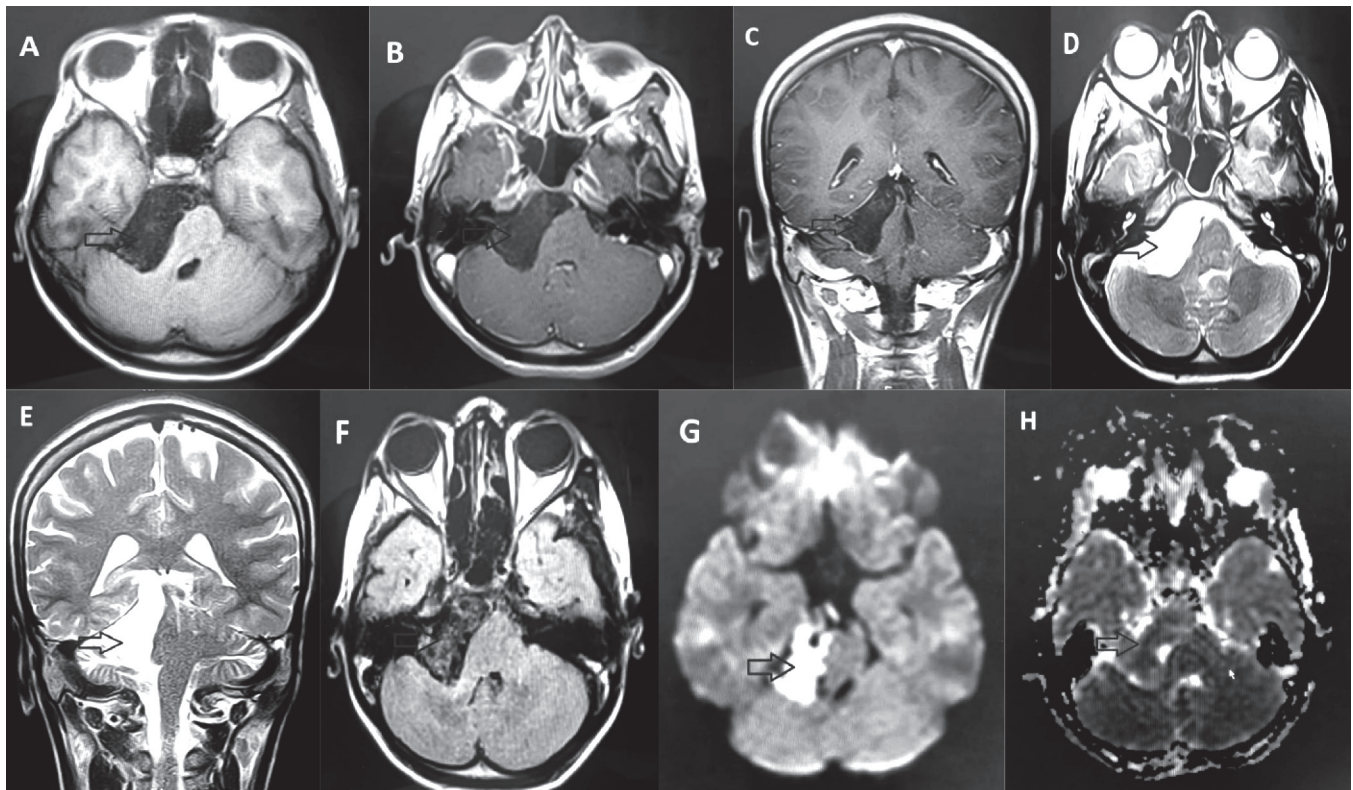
MRI examination
